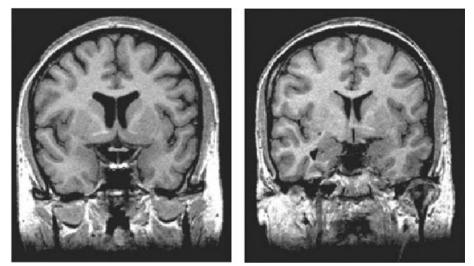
Magnetic reconance imaging (MRI) of a normal brain (left) and a brain of a person with schizophrenia (right) from the Maudsley Family Study. (Adapted from McDonald et al., 2002)
